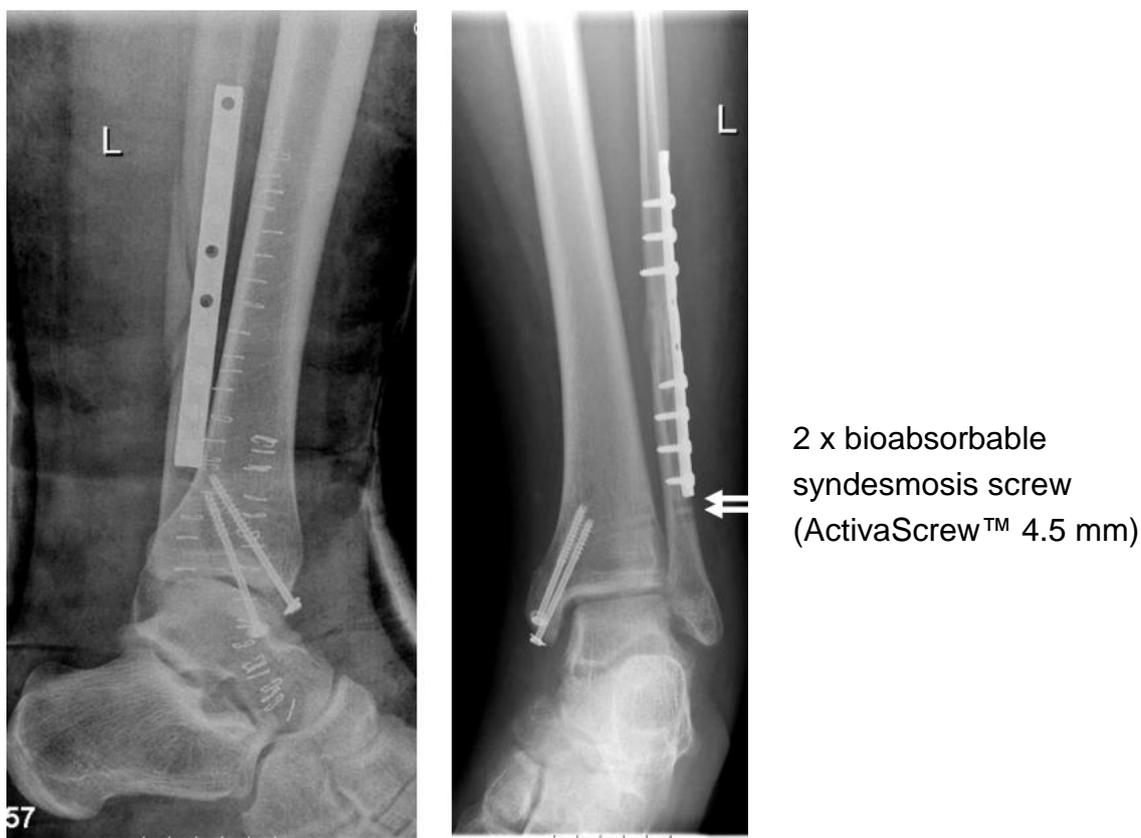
Postoperative X-ray for Case 1.
